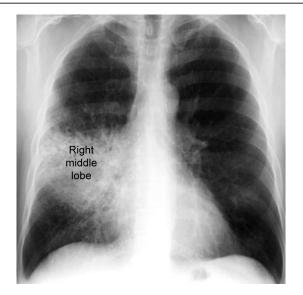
Chest X-ray with silhouetted out the right border of heart
